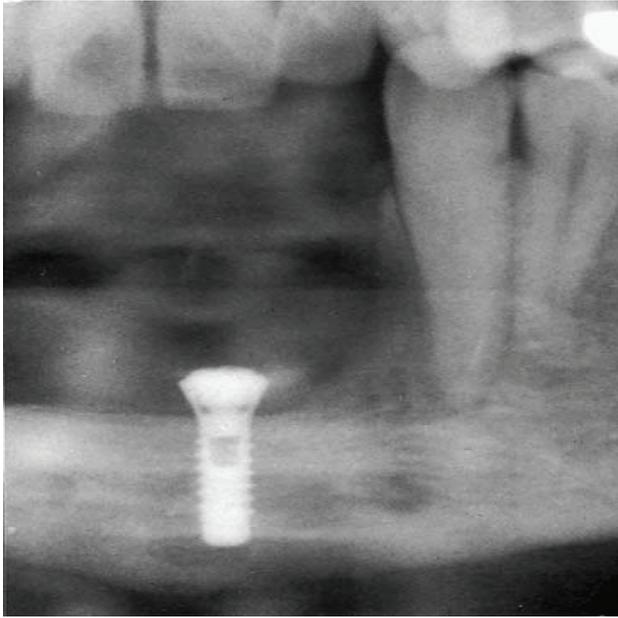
Radiograph demonstrating a step between the remaining dentate mandible (right) and the fibula bone graft (left)
